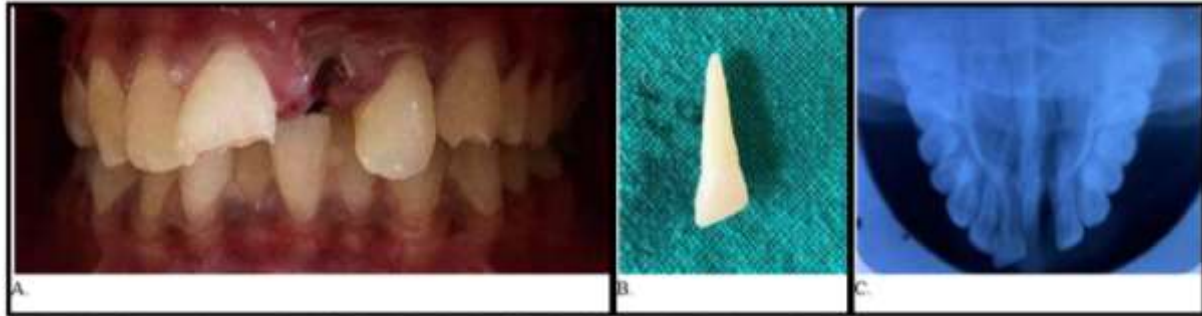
A. Avulsion seen in a young boy (21), B. Avulsed tooth, C. Occlusal Radiograph showing no alveolar fracture.
